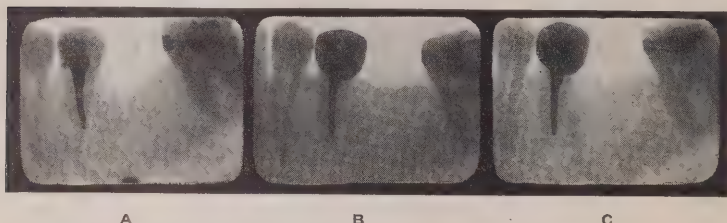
(Gunton)—(a) Devitalization, arsenic, Oct. 13, 1921. Failed to get a good filling in canal, Oct. 27, 1921. The following day removed the gutta percha and filled with copper amalgam, X-rayed; (b) shows condition Dec., 1923; (c) shows condition, Jan. 30, 1925. Note: The perfect condition of the periapical tissues. Arsenic, devitalization and the filling short of the apex allowing calcific closure.
